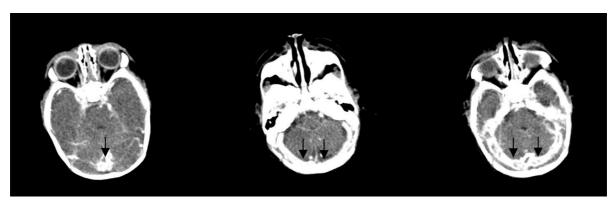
Contrast-enhanced brain computerized tomography (CT) on day 2 of hospitalization. showing diffuse dural sinus thrombosis in the superior sagittal, straight, and bilateral transverse sinuses (black arrow).
